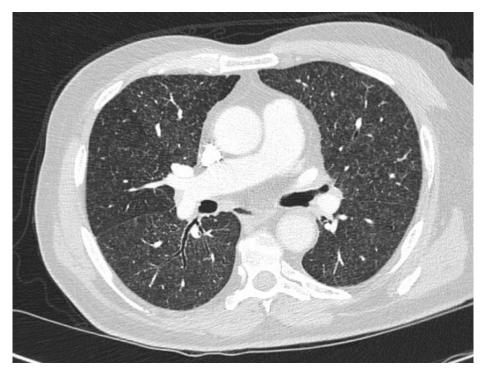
CT angiography of the chest showing diffuse random pulmonary nodules without lobar predominance on a background of faint ground glass opacity as well as bilateral peribronchial and peribronchiolar wall thickening.
